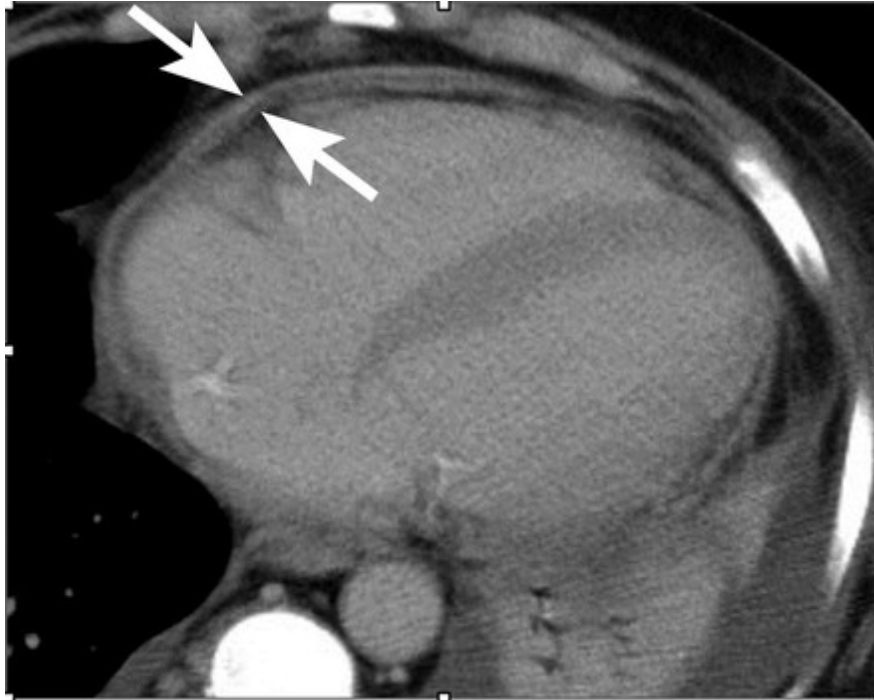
Axial contrast-enhanced CT scan shows pericardial thickening (arrows
